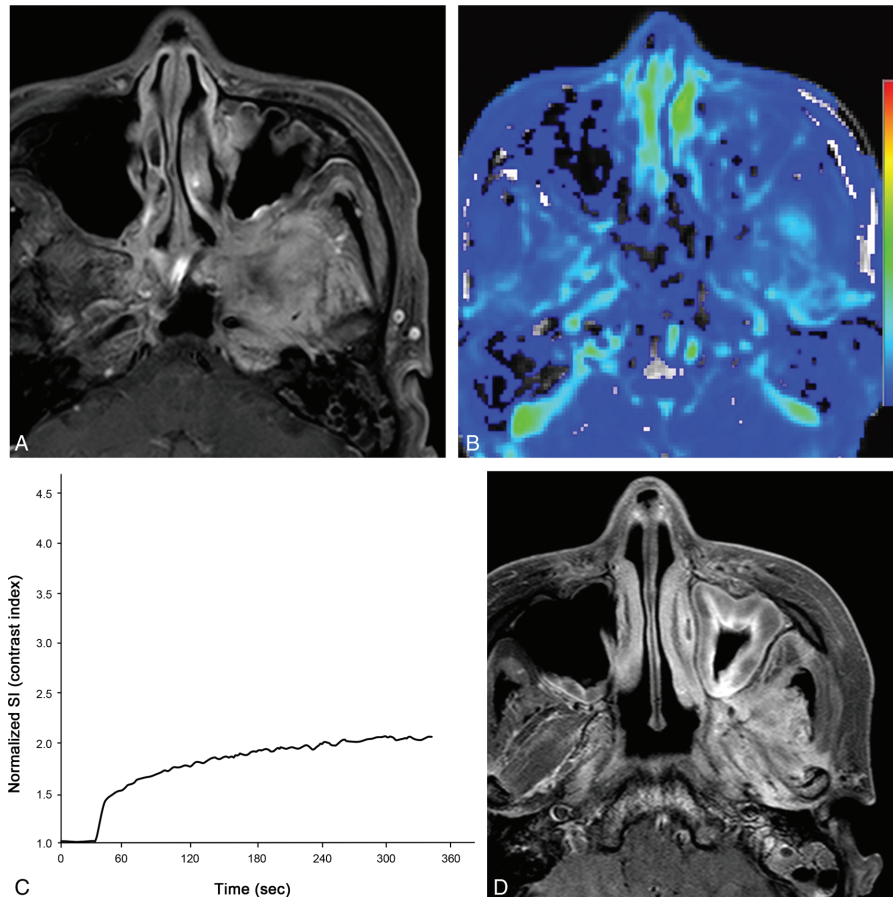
Posttreatment change of maxillary sinus cancer in a 38-year-old woman. (A) Contrast-enhanced T1-weighted MRI showing a retracted mass with enhancement in the infratemporal fossa after treatment. (B) AUC60 map derived from DCE-MRI analysis showing a relatively slow visual increase in AUC in the corresponding areas of the contrast-enhancing lesion. (C) TSI curve of the entire enhancing lesion showing a progressive increment (type I), and an AUC60 value of 28.49. (D) 82-week follow-up MRI showing a reduction in mass size, thus suggesting posttreatment change. AUC = area under the curve, DCE-MRI = dynamic contrast-enhanced magnetic resonance imaging, MRI = magnetic resonance imaging, TSI = time-signal intensity.
